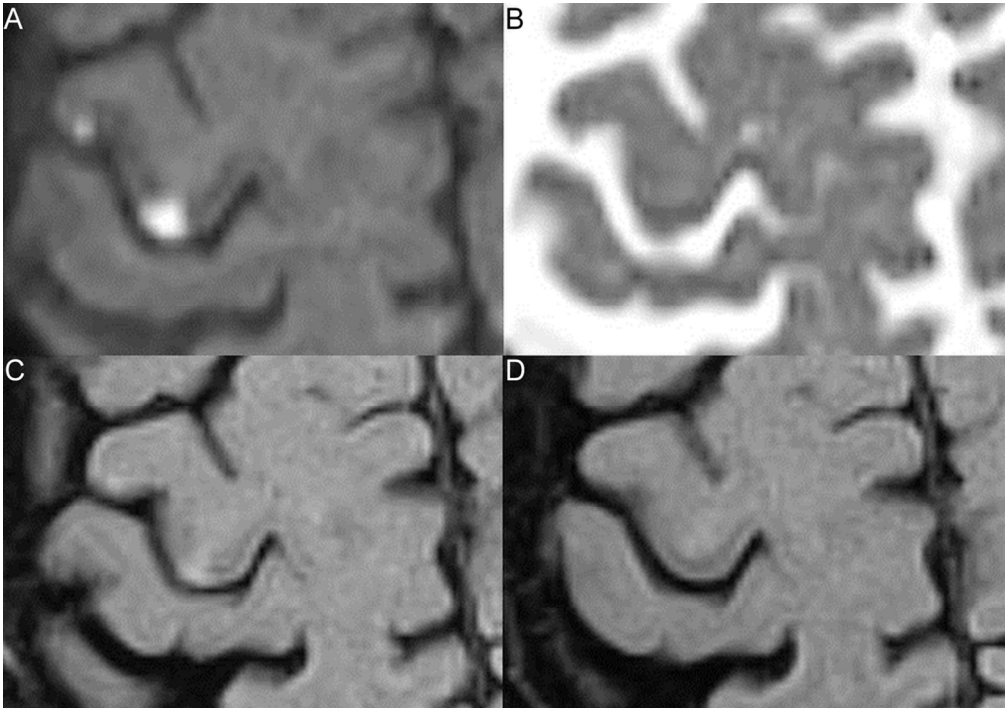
Lesions with and without 8-week infarction signs. Two cortical gray matter lesions are shown on initial DWI (panel A), ADC (panel B), initial FLAIR (panel C) and 8-week FLAIR (panel D). Panel A: Both lesions are DWI-positive. Panel B: The medial lesion is ADC-confirmed, the lateral lesion shows no ADC-confirmation. Panel C: Both lesions are initially FLAIR-positive. Panel D: the medial lesion is 8-week FLAIR-positive, the lateral lesion is 8-week FLAIR-negative.
